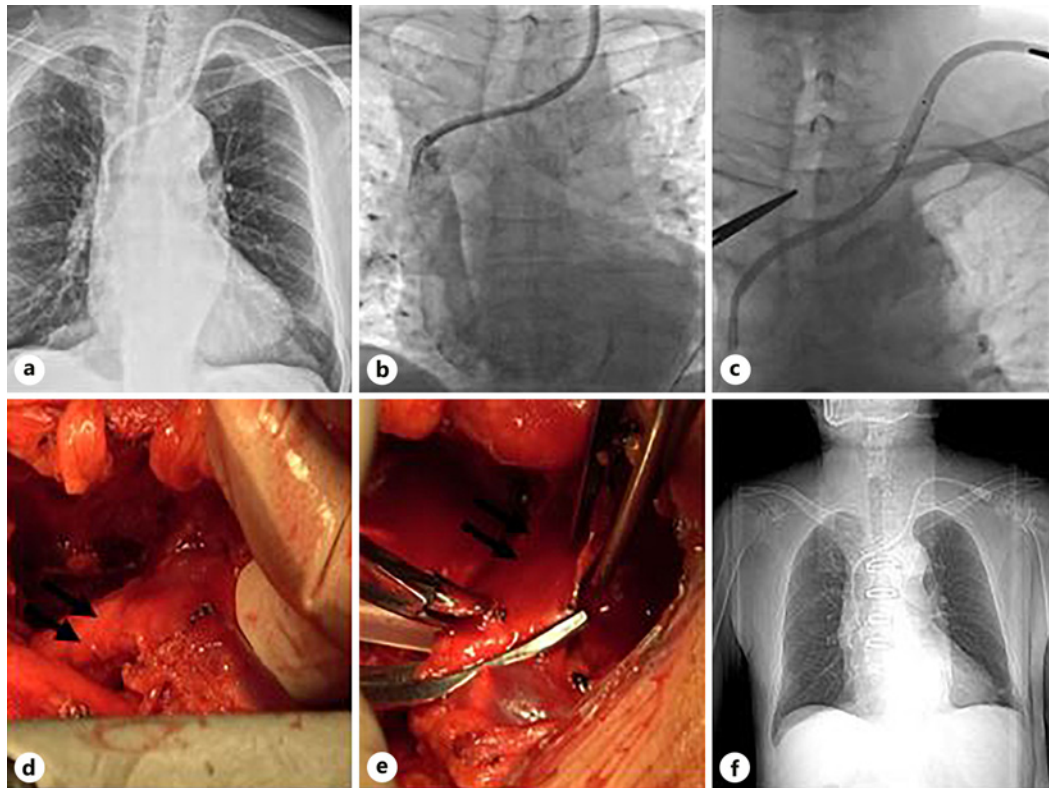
Preoperative, intraoperative, and postoperative catheter status of the second patient. a Angiography showed the position of long-term hemodialysis catheter in the left internal jugular vein before surgery (the end of the catheter was flush with the level of the 7th thoracic vertebra). b Angiography showed that the patient's superior vena cava had no obvious stenosis. c Intraductal balloon dilatation was performed to assist extubation under DSA. d, e Fibrin sheath was found around the catheter during thoracotomy. f X-ray showed the postoperative position of long-term hemodialysis catheter in the left internal jugular vein (the end of the catheter was located in the shadow of the right atrium, which was flush with the upper border of the 10th thoracic vertebra).
